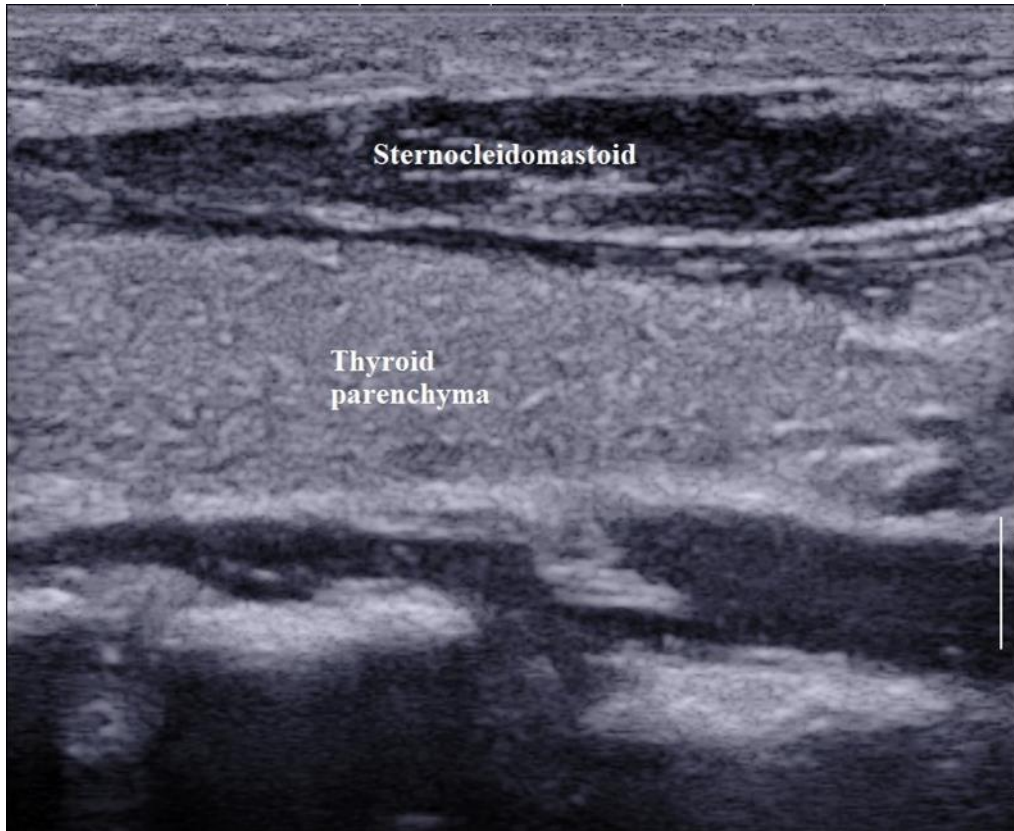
Grey-scale ultrasound Longitudinal section of left lobe of the normal thyroid gland
